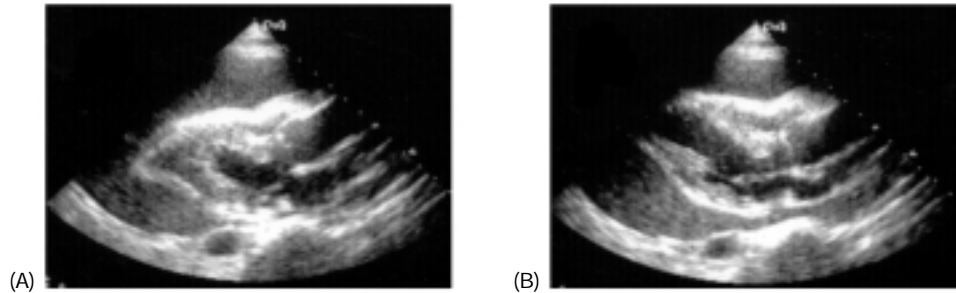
Parasternal long-axis views in end-diastole (A) and end-systole (B). Prepericardiocentesis frames demonstrating normal left ventricular systolic function with large pericardial effusion and right ventricular diastolic compression. The walls of the left ventricle are thickened.
